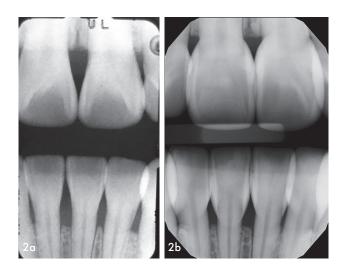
Preoperative (2a) and six-year radiographs (2b) of the case in Figure 1. After viewing the radiographic integrity and the long-term favorable soft tissue response, most periodontists and orthodontists feel comfortable with this method as a conservative, permanent and healthy option. This flowable comes in the same Body shade, which allows an ideal match between the different viscosity resins.
